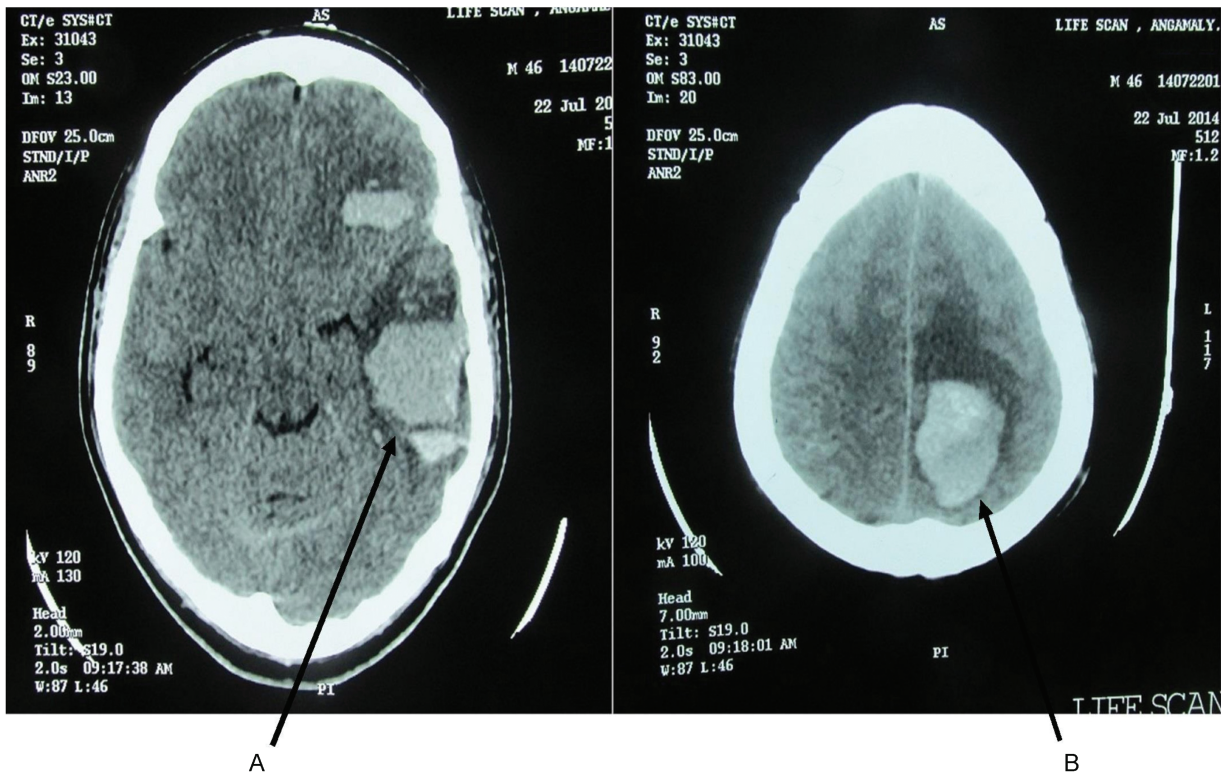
Repeat CT scan of the brain. (A) A large intracerebral hemorrhage in the left temporal lobe and (B) another large intracerebral hemorrhage in the left parietal lobe with significant mass effect and signs of early transtentorial herniation. CT, computed tomography.
